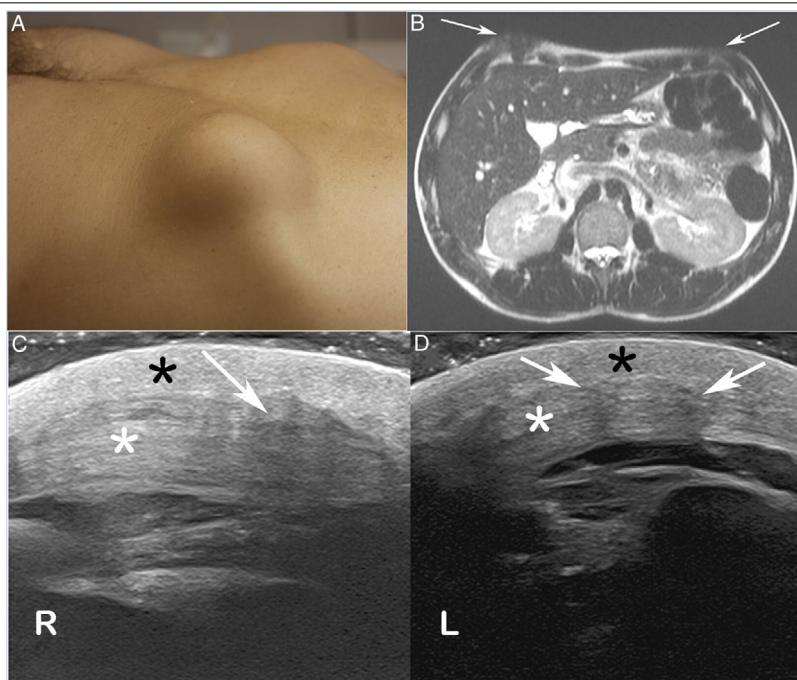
(A) Photograph of the patient's chest, showing a round mass in the right hemithorax, anterior to the lower ribs. (B) T2-weighted magnetic resonance image showing the low signal intensity of the lesions (arrows). Ultrasonography of the lower right (C) and left (D) hemithoraces revealed hypoechoic masses (arrows) with surrounding dermal (black asterisks) and subcutaneous (white asterisks) thickening.
